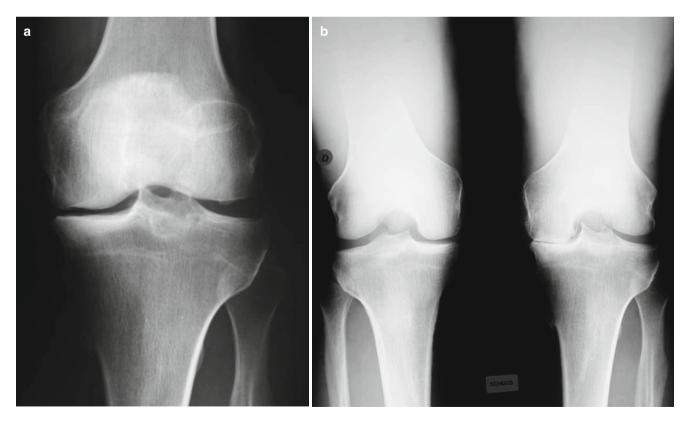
Full weight-bearing X-rays. (a) AP view. (b) Schuss view at 45° of flexion. (c) Lateral view (30° of flexion)
